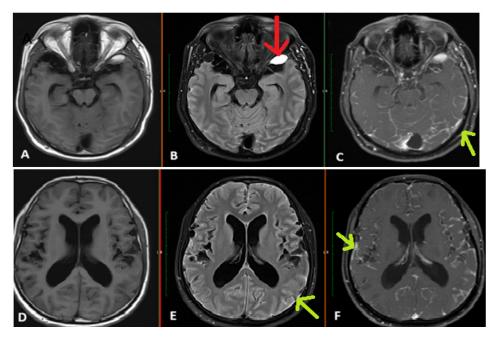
MRI Brain (T1W, T2 FLAIR, and post contrast) showing one cystic locule at the left anterior temporal convexity with internal T1 hyperintensity. [(B), red arrows] Diffuse thick leptomeningeal enhancement is seen along bilateral cerebral sulcal spaces and cerebellar folia, with adjacent dural enhancement. [(C), (D), and (E), green arrows].
